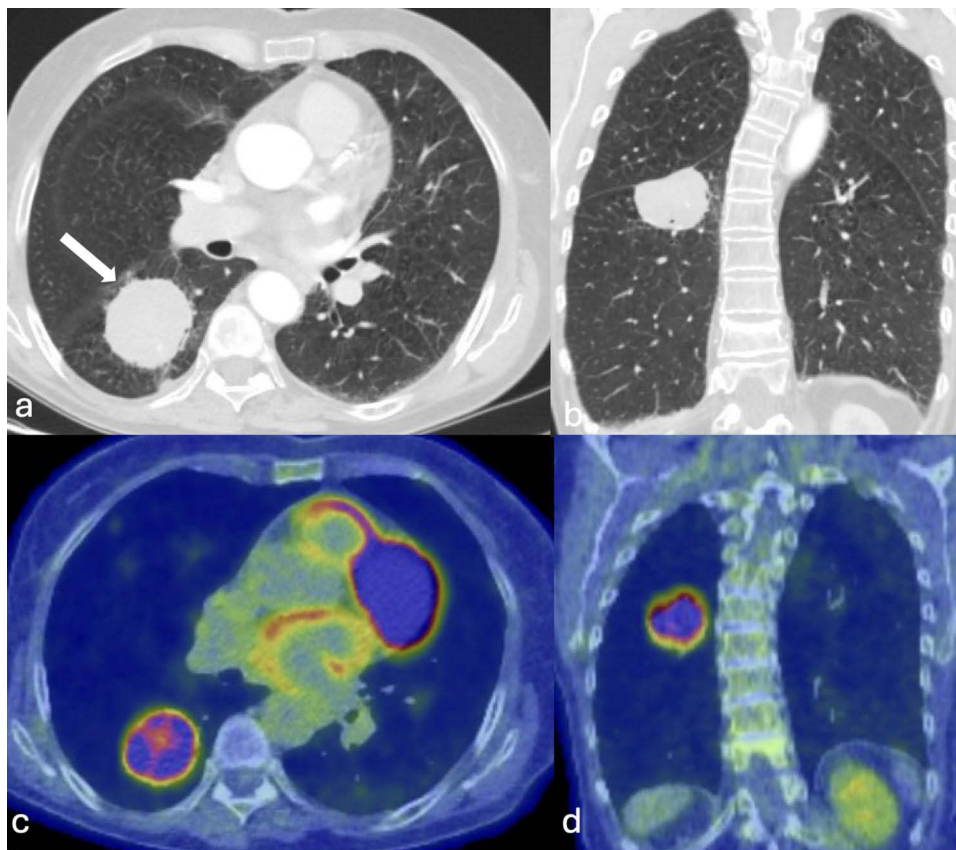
Chest CT axial (a) and coronal (b) reconstructions demonstrating a large mass in the superior segment of the right lower lobe (white arrow). The lesion was metabolically active on PET-CT (SUVmax 9.3) (c and d) with a central area of relative photopenia, suggestive of necrosis.
